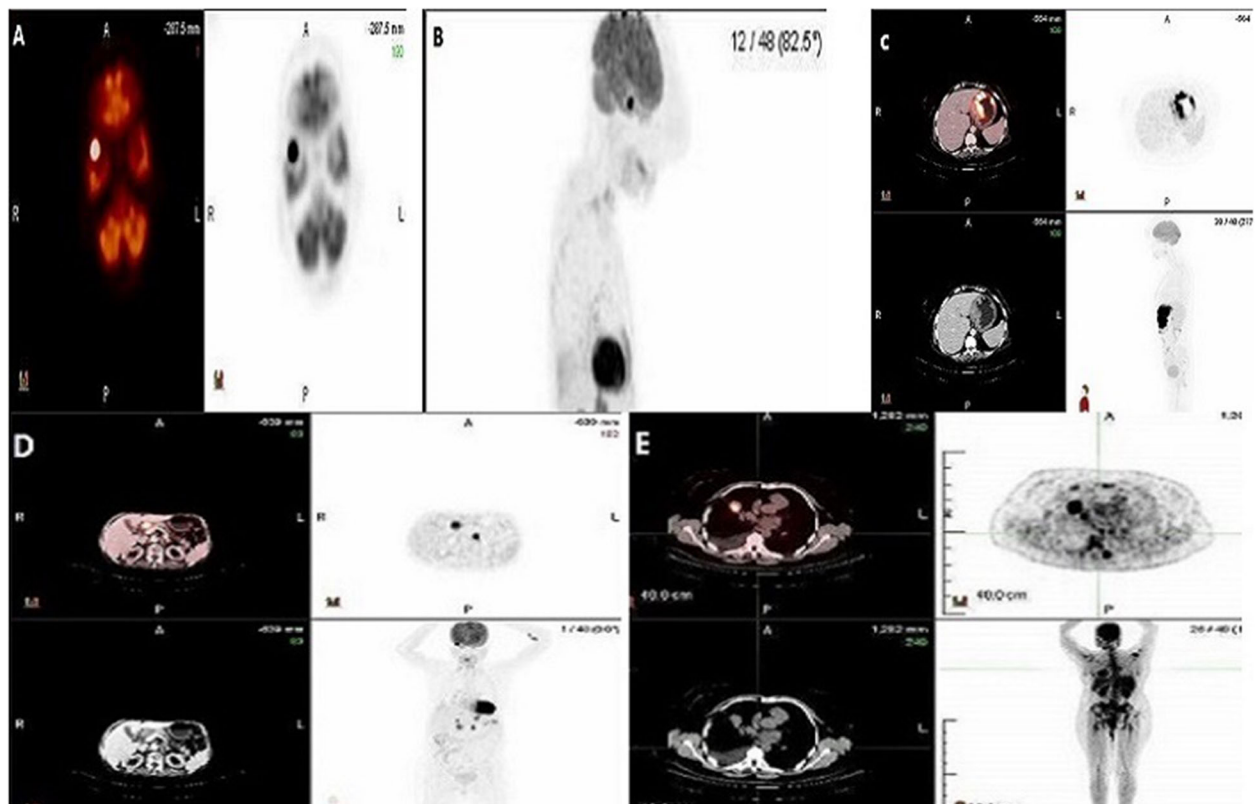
Right temporal lesion incidentally detected in a female patient aged 57 years by CT scan. a, b Axial fused PET/CT and axial and sagittal PET scan showed a single metastatic mass lesion in the right temporal lobe with active FDG uptake. c Axial fused PET/CT and CT scan showed nodular gastric wall thickness seen mainly in the body with active FDG uptake proved by gastroscopic biopsy to be gastric adenocarcinoma and considered the primary tumor. d Axial fused PET/CT and CT scan showed active porta hepatis and left retrocaval metastatic lymph nodes. e Axial fused PET/CT and CT scan showed another active metastatic mass in the right lung field
